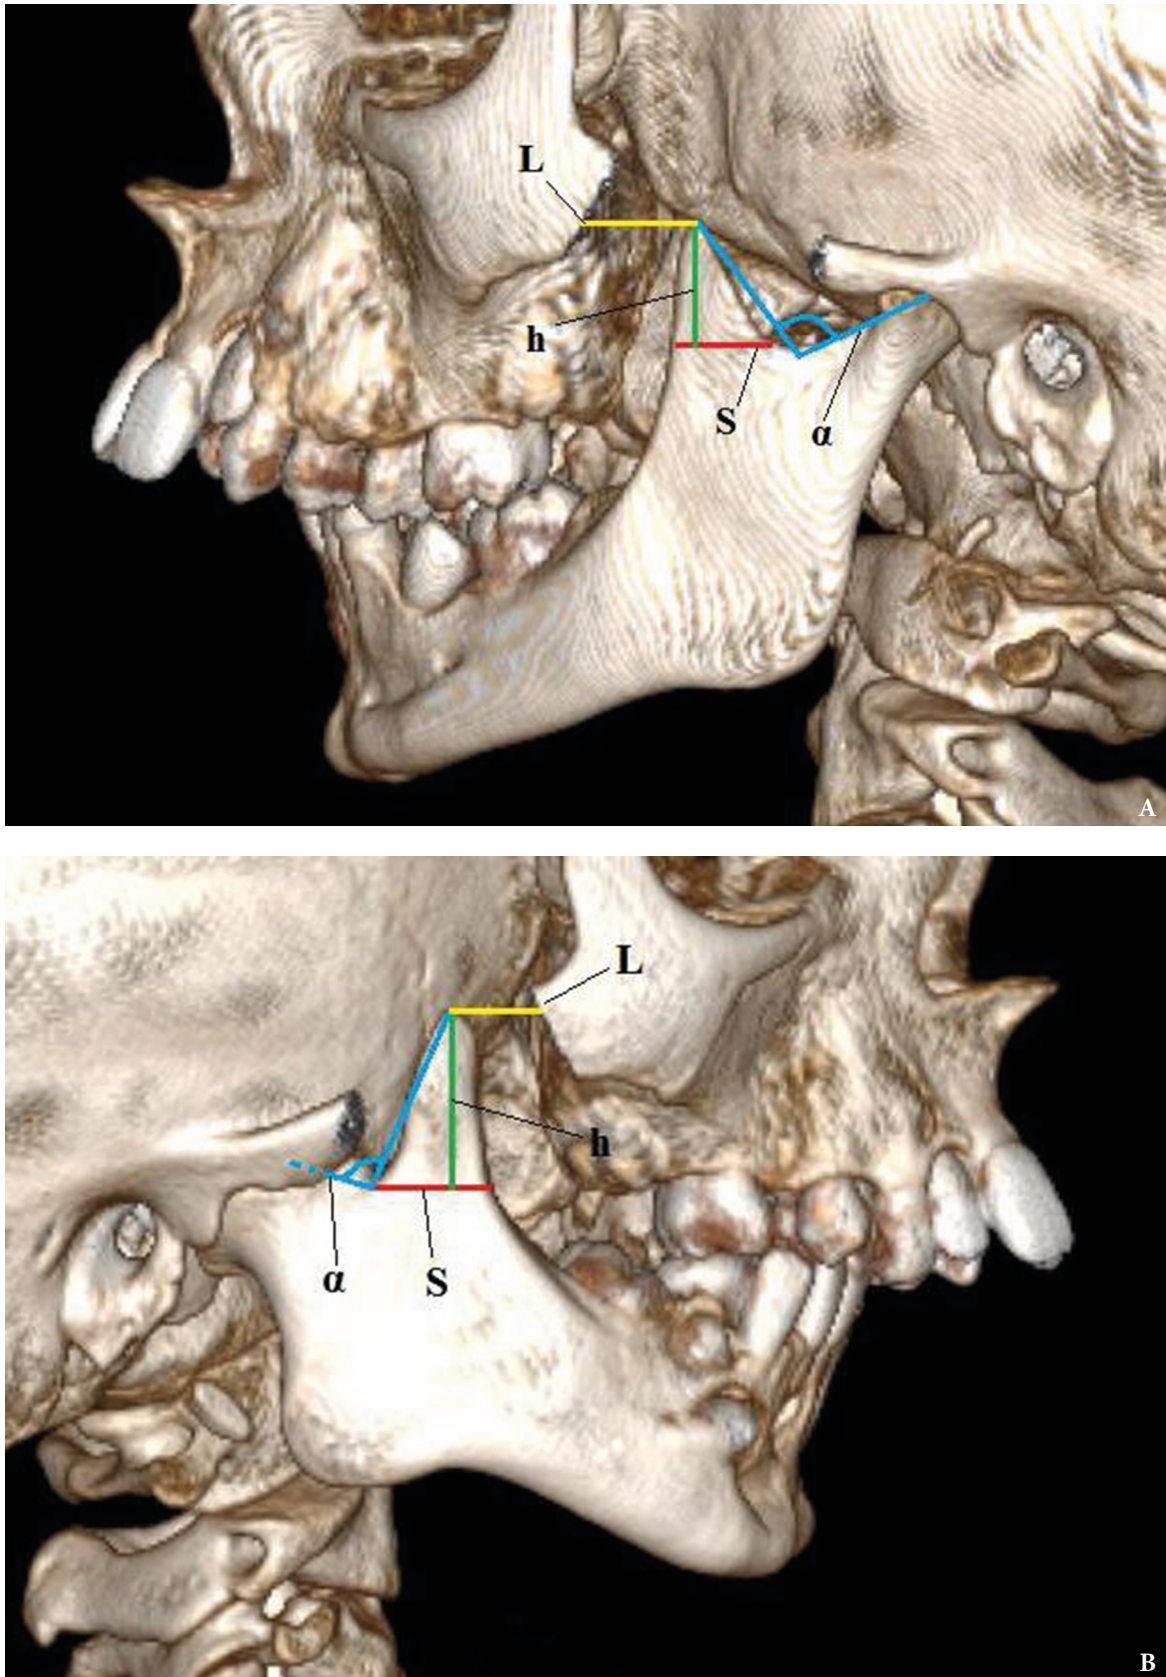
3D reconstructed CT image. Scheme of anthropometric measurements of explosives according to the proposed modification. The height ( $h$ ) of the CP was determined as the perpendicular that was lowered from the top of the coronoid process to the red line  $S$ . The angle  $\alpha$  – formed between blue lines (CP and the condylar process) had sides passing between the highest points of the processes of the mandible and the lowest point of the incisure of mandible. Additionally, measure the distance  $L$  (yellow line), which was determined between the top of the CP and the inner surface of the zygoma, as an indicator of the degree of mobility of the mandible.
